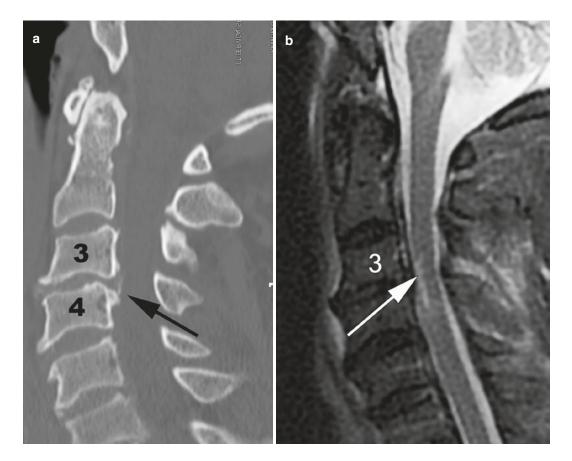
(a) A 67-year-old female had a ground-level fall and presented with a central cord syndrome. Her lower extremities had Grade 3-4 motor function, there was no hand function and Grade 2 motor function in deltoid and biceps muscles. The sagittal CT shows no fracture or subluxation. There is ossification of the posterior longitudinal ligament at C3-4 (arrow)and a narrow spinal canal. (b) T2 fat-suppressed MRI demonstrates spinal stenosis with increased signal at C3-4 in the anterior aspect of the cord. (c) Postoperative lateral radiograph after laminoplasty C3-C6 and reconstruction with plates. (d) T2 MRI one year after injury showing bright cord signal changes at C3-4 but resolution of spinal stenosis. She had made significant neurologic recovery except in hands but is living independently
